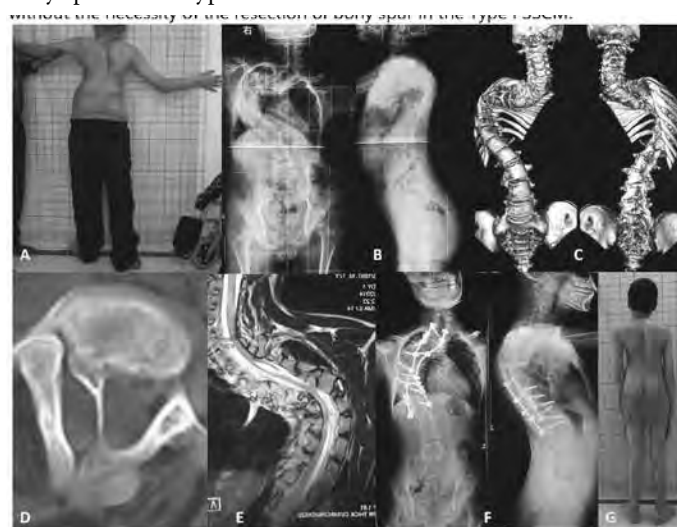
Before the operation B. Initial AP and lateral standing X-rays of the patient. C. 3D-CT scan image. D. CT scan of the cross-section of the vertebral body. E. MRI of the spine. F. Standing AP and Lateral X-rays 2 years after surgery, G. 2 years after
